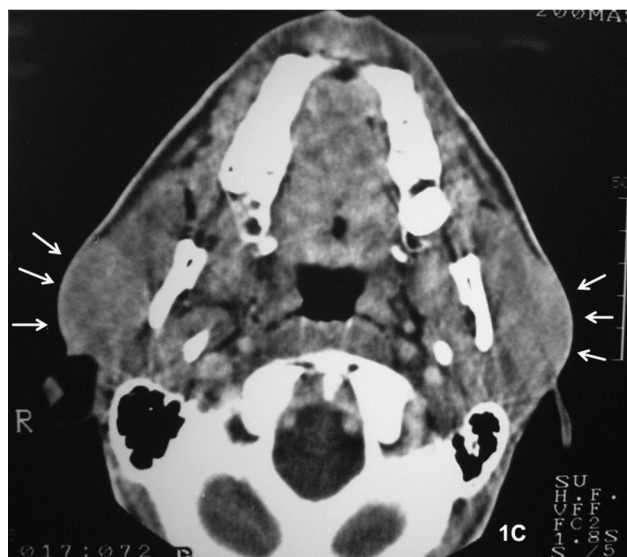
Helical computed tomography of the soft tissues viewed with window scans clearly shows enlargement of the parotid glands (arrows). There is increased density in both glands, but no sign of intraglandular lesions.
